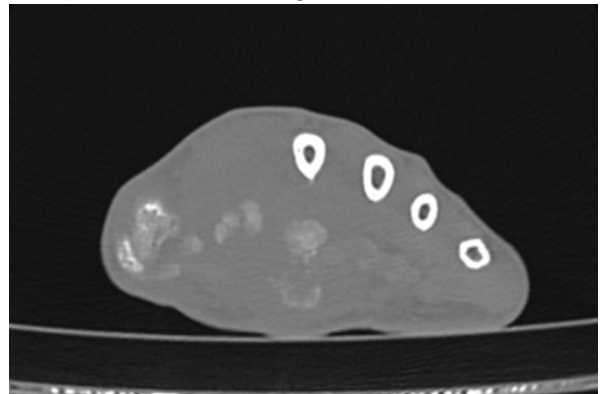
CT Scan Plain Showing Few Irregular Hypointense Foci Within The Thenar Muscles Suggestive Of Calcification.
